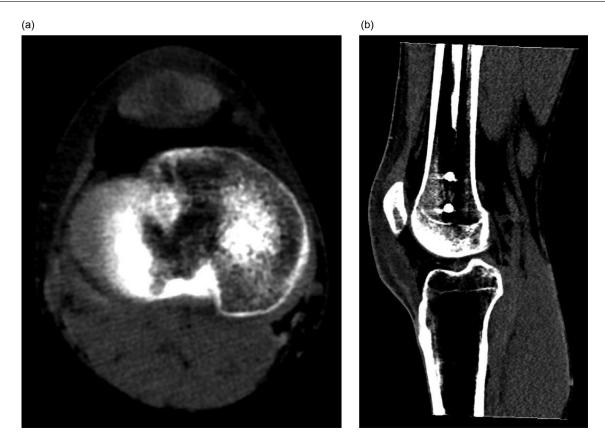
Contrast-enhanced computed tomography of right knee. Axial slice through the mid patellar tendon shows an abnormal focus of low attenuation in the center of the tendon (a). Sagittal slice through the patellar tendon demonstrates the elongated low attenuation fluid collection with subtle peripheral enhancement as well as prepatellar soft tissue thickening (b).
